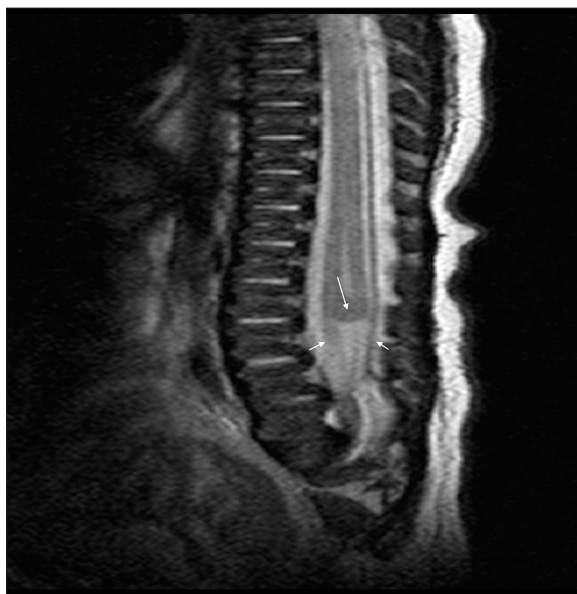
MRI of the lumbar vertebral column in a 10-month-old male infant revealed sacrococcygeal hypoplasia with a blunt-ending, club-shaped conus medullaris (larger arrow) with double-bundle arrangement of the nerve roots (smaller arrows)
